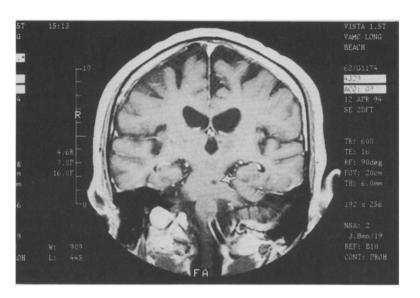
Coronal T₁-weighted MRI of the brain demonstrating left pontine infarct (arrow).
